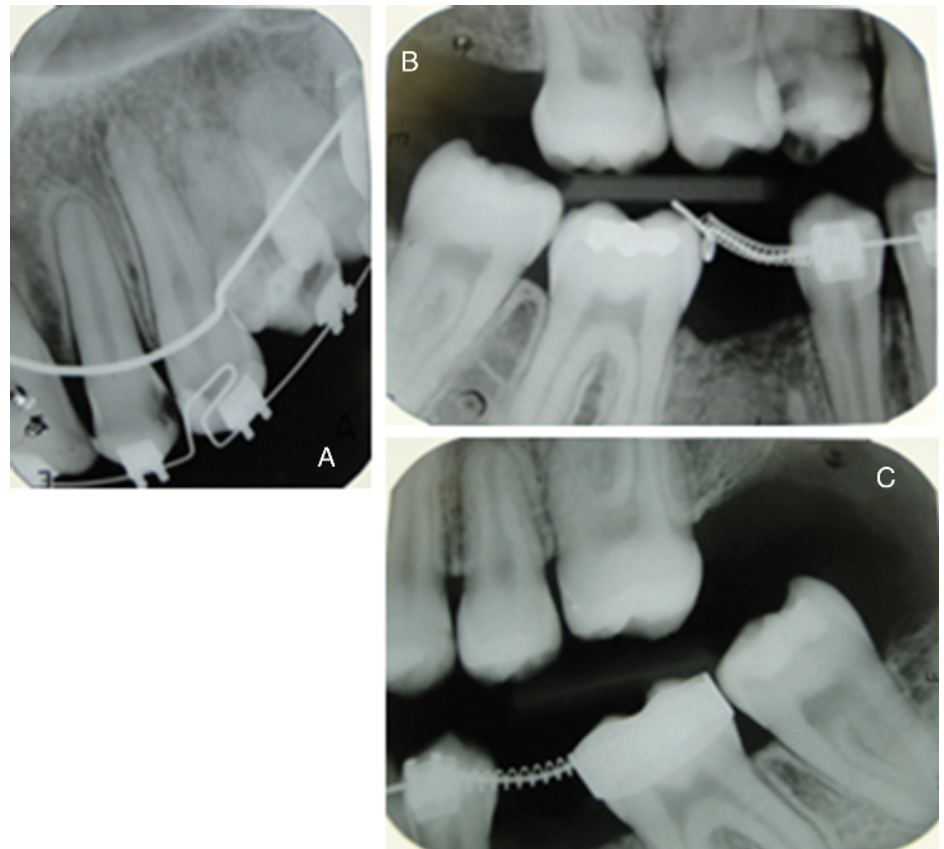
(A) Periapical radiograph shows deep caries that will need root canals treatment. (B), (C) Bite-wing radiography shows deep caries that will need root canals treatment.
